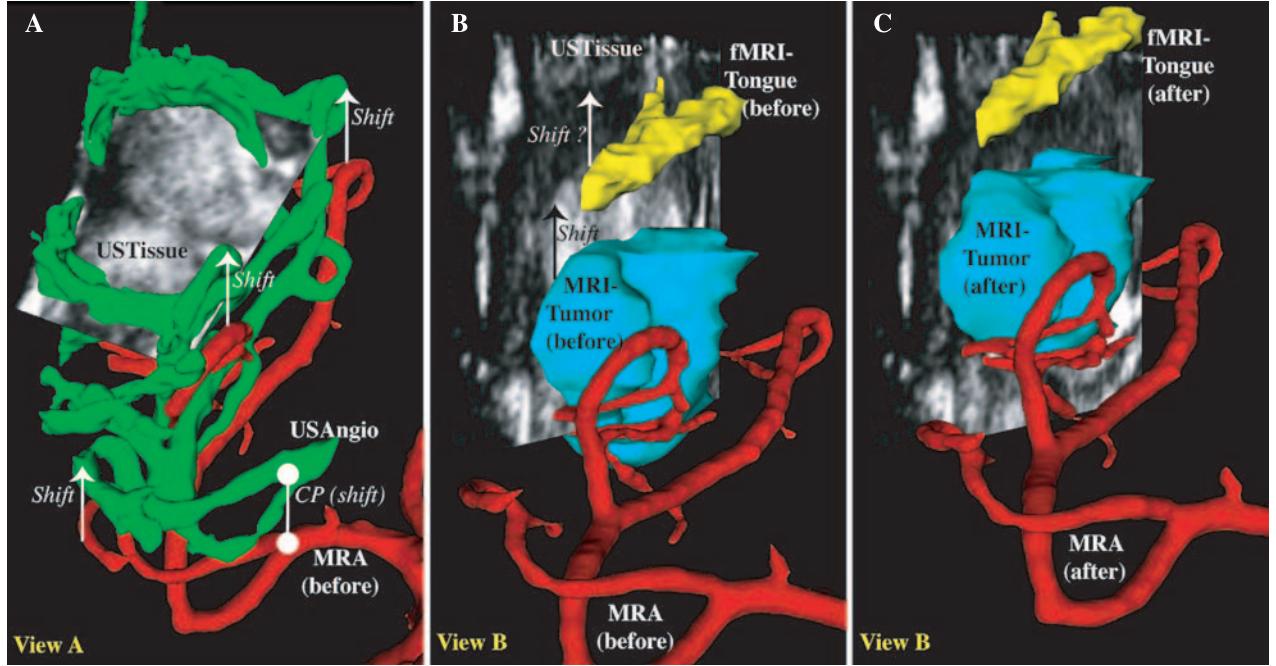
The use of intra-operative 3D ultrasound to update essential pre-operative data due to anatomical changes that occur during surgery (patient #1). (A) Even before surgery starts, considerable shift between pre-operative MRA (red) and intra-operative ultrasound angiography (green) can clearly be observed by looking at identical structures in the two datasets. (B) Before brain shift compensation ultrasound tissue data disclosed a mismatch when compared with the segmented MRI tumor border (blue). Furthermore, the tongue activation appeared to be inside the tumor as depicted by ultrasound. Obviously this is not the case as can be seen in (C) where both structural and functional MR data have been moved according to the mismatch detected by the automatic registration algorithm
